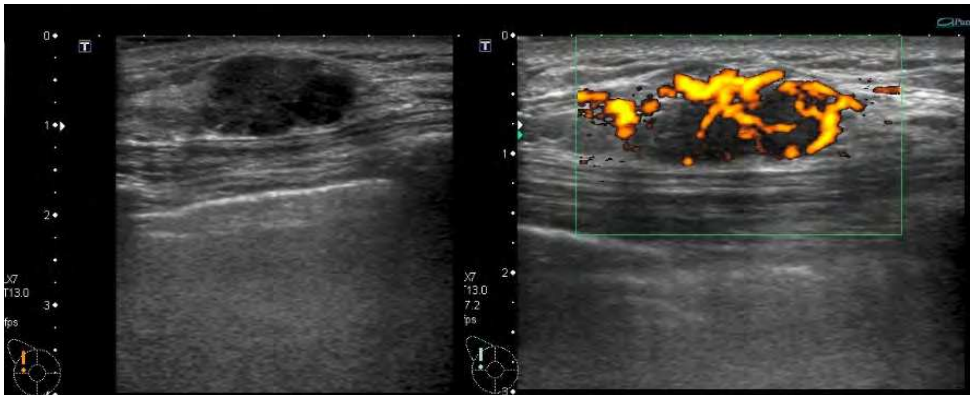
A second representative case of IDC, Ultrasound; B-mode and power Doppler view.
